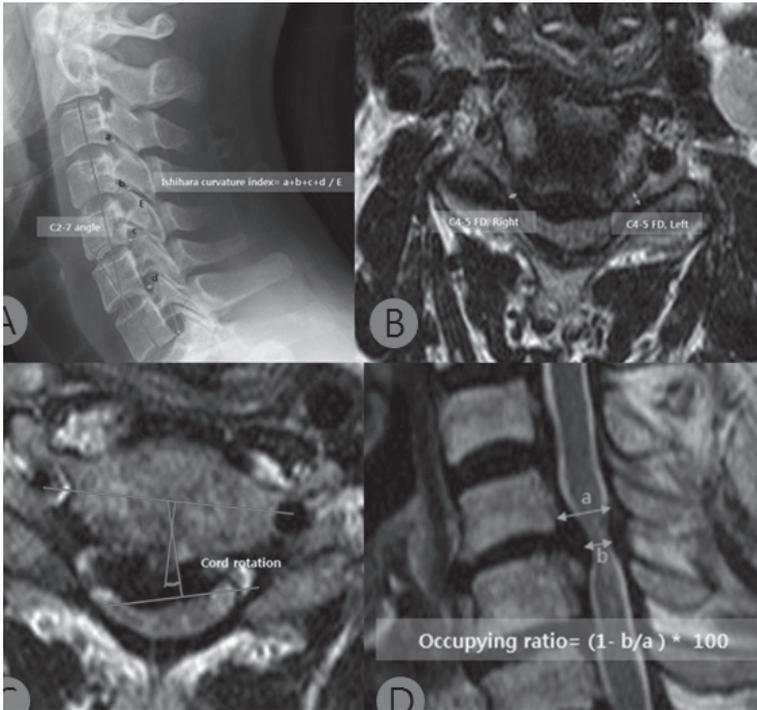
Measurement and analysis of radiographic data. A; C2-7 angle and Ishihara's curvature index, B; transforaminal diameter of C4-5, C; occupying ratio and T2HIZ, D; cord rotation.
